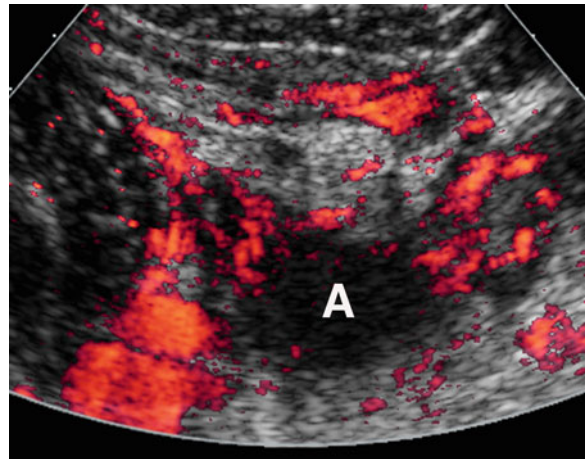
Periappendiceal abscess as hypoechoic mass. Note hypoechoic mass representing abscess (“A”) on transverse power-Doppler sonogram, surrounded by inflamed echogenic mesenteric and omental fat on power-Doppler sonogram. There is marked hyperemia within inflamed fat
